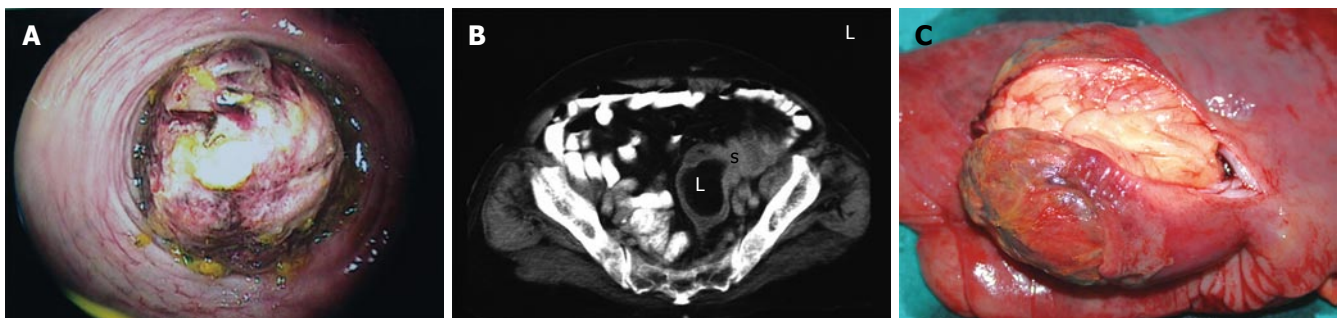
Colonoscopic appearance of a broad-based giant mass acquiring spontaneous hemorrhagic areas and obstructing more than 75% of the lumen of sigmoid colon (A); abdominal computed tomography scans showing the diffuse thickening of sigmoid colon wall, invagination and a distal intraluminal giant mass with fat density with a size of approximately 6 cm x 7 cm (B); macroscopic appearance of the giant sigmoid colon lipoma (C).
